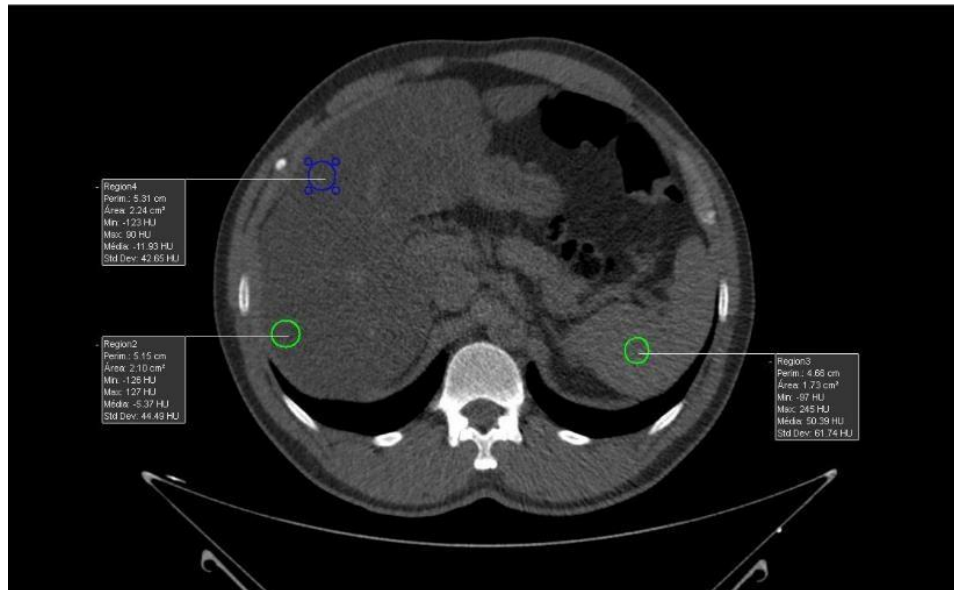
65-year-old man with hepatic steatosis. Attenuation of the liver (regions 2 and 4) and spleen (region 3) was assessed using region of interest tools in post-processing programs. CT, computed tomography.
